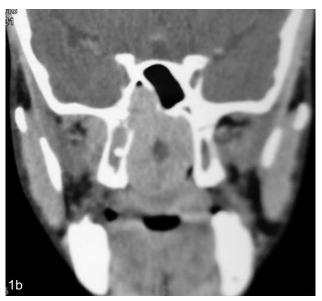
Axial (a) and coronal (b) contrast enhanced CT images showing enhancing soft tissue mass in nasal cavity extending into nasopharynx, pterygopalatine fossa and infratemporal fossa. The mass is causing deviation of nasal septum to the right.
